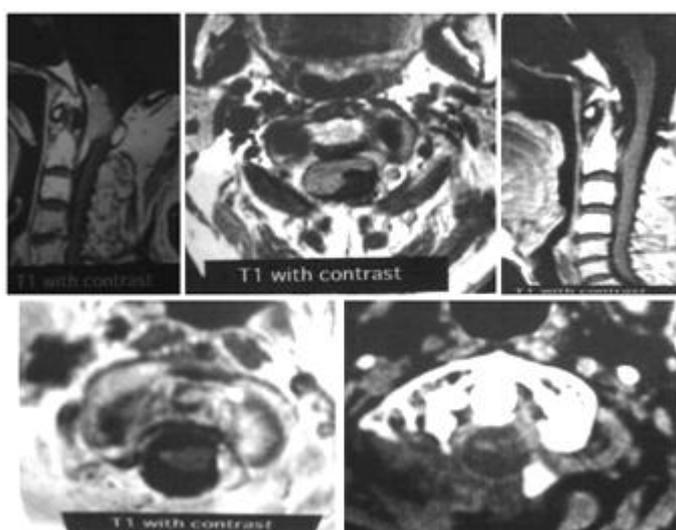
pre and post operative MRI of a case of anterior foramen magnum meningioma.
